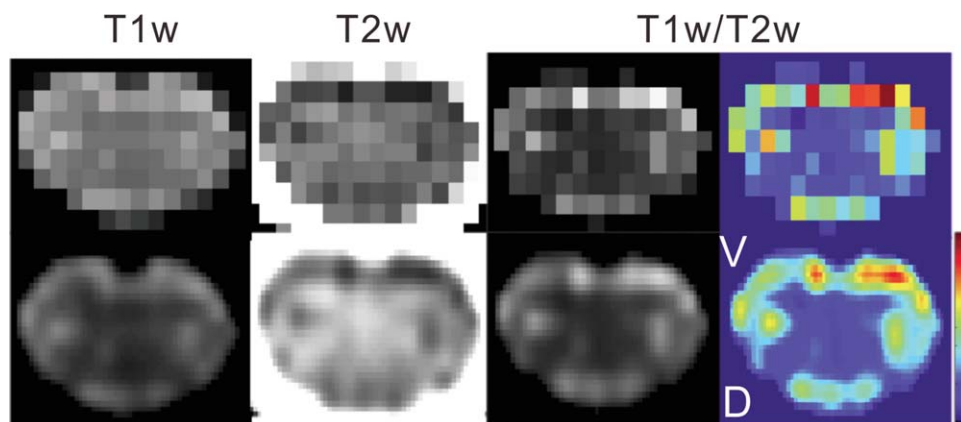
Comparison of the ratio images with the original MR images. The original resolution (1×1 mm) image (top) and the high resolution (0.25×0.25 mm) images for the T1w, T2w, and T1w/T2w ratio MRIs (bottom) are shown for the same cervical segment (C4) in one representative healthy subject. Contrast between the GM and WM is the highest for the T1w/T2w ratio images. The scale for each image is 10–90%.
